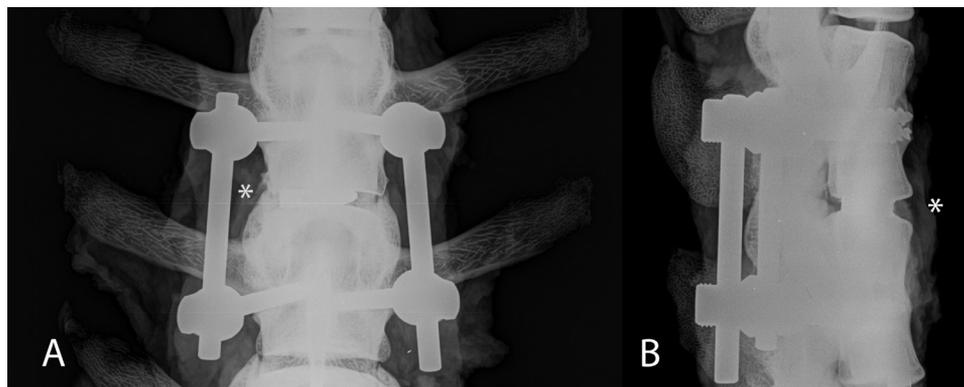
Posteroanterior (A) and lateral (B) Faxitron radiographs at 12 weeks of the interbody fusions revealed the presence of the implant (\*) and the pedicle screws while detection of bone at the endplate interface or inside the cage itself was not possible.
